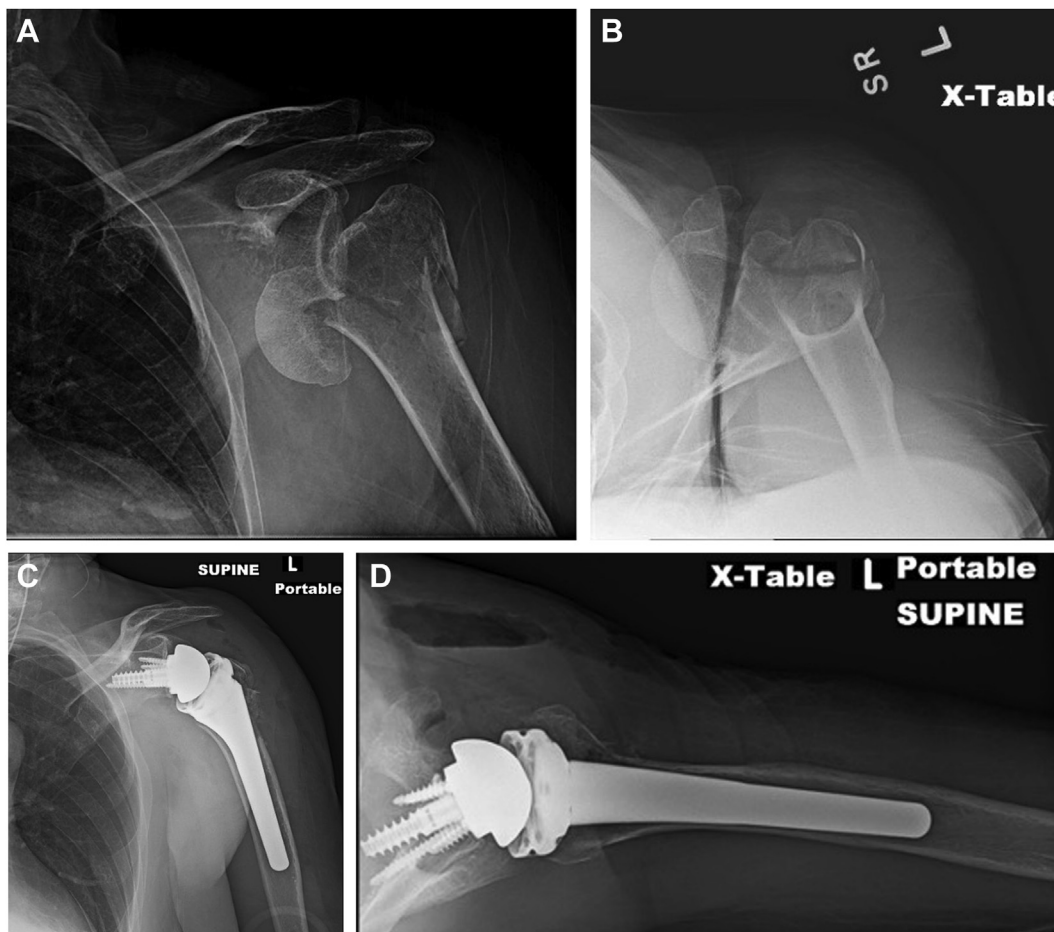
(A, B) Preoperative radiographs of a 78-year-old woman with a left proximal humerus fracture dislocation. (C, D) Postoperative radiographs demonstrate greater and lesser tuberosity reduction after RSA. RSA, reverse total shoulder arthroplasty.
